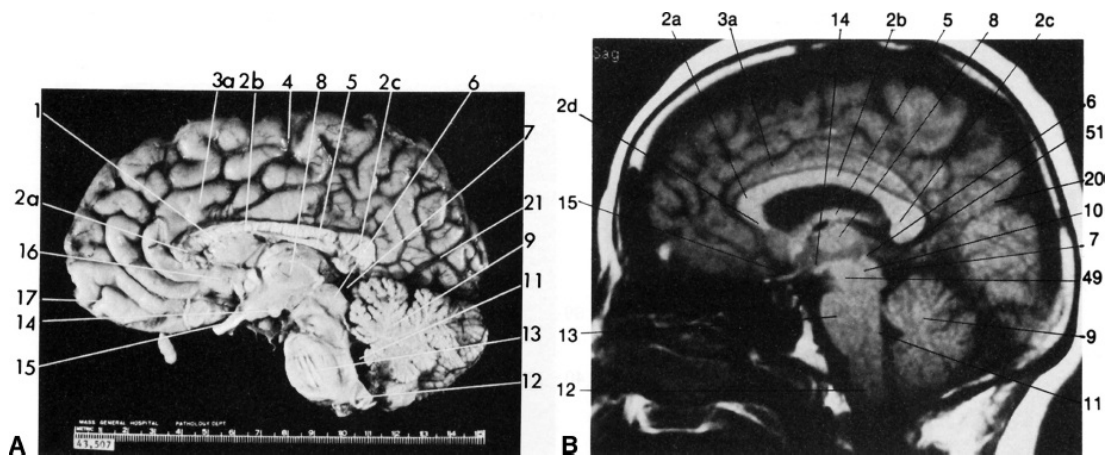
A. Gross brain. B. T1-weighted MR image. Approximately matched midline sagittal sections. Sagittal T1-weighted MRI of the brain and upper cervical spinal cord. Labels: 1, septum pellucidum; 2, corpus callosum (a, genu; b, body; c, splenium; d, rostrum); 3, cingulate gyrus; 4, central sulcus; 5, column of fornix; 6, quadrigeminal plate; 7, quadrigeminal cistern; 8, thalamus; 9, cerebellum; 10, aqueduct of Sylvius; 11, fourth ventricle; 12, medulla; 13, pons; 14, mammillary body; 15, optic tract; 16, olfactory area; 17, gyrus rectus; 20, parietal-occipital fissure; 21, calcarine fissure; 49, midbrain; 51, pineal gland. (Reprinted with permission from Barboriak DP, Taveras JM. Normal cerebral anatomy with magnetic resonance imaging. In: Ferrucci JT, ed. *Taveras and Ferrucci's Radiology on CD-ROM*. Philadelphia: Lippincott Williams & Wilkins, 2003.)
